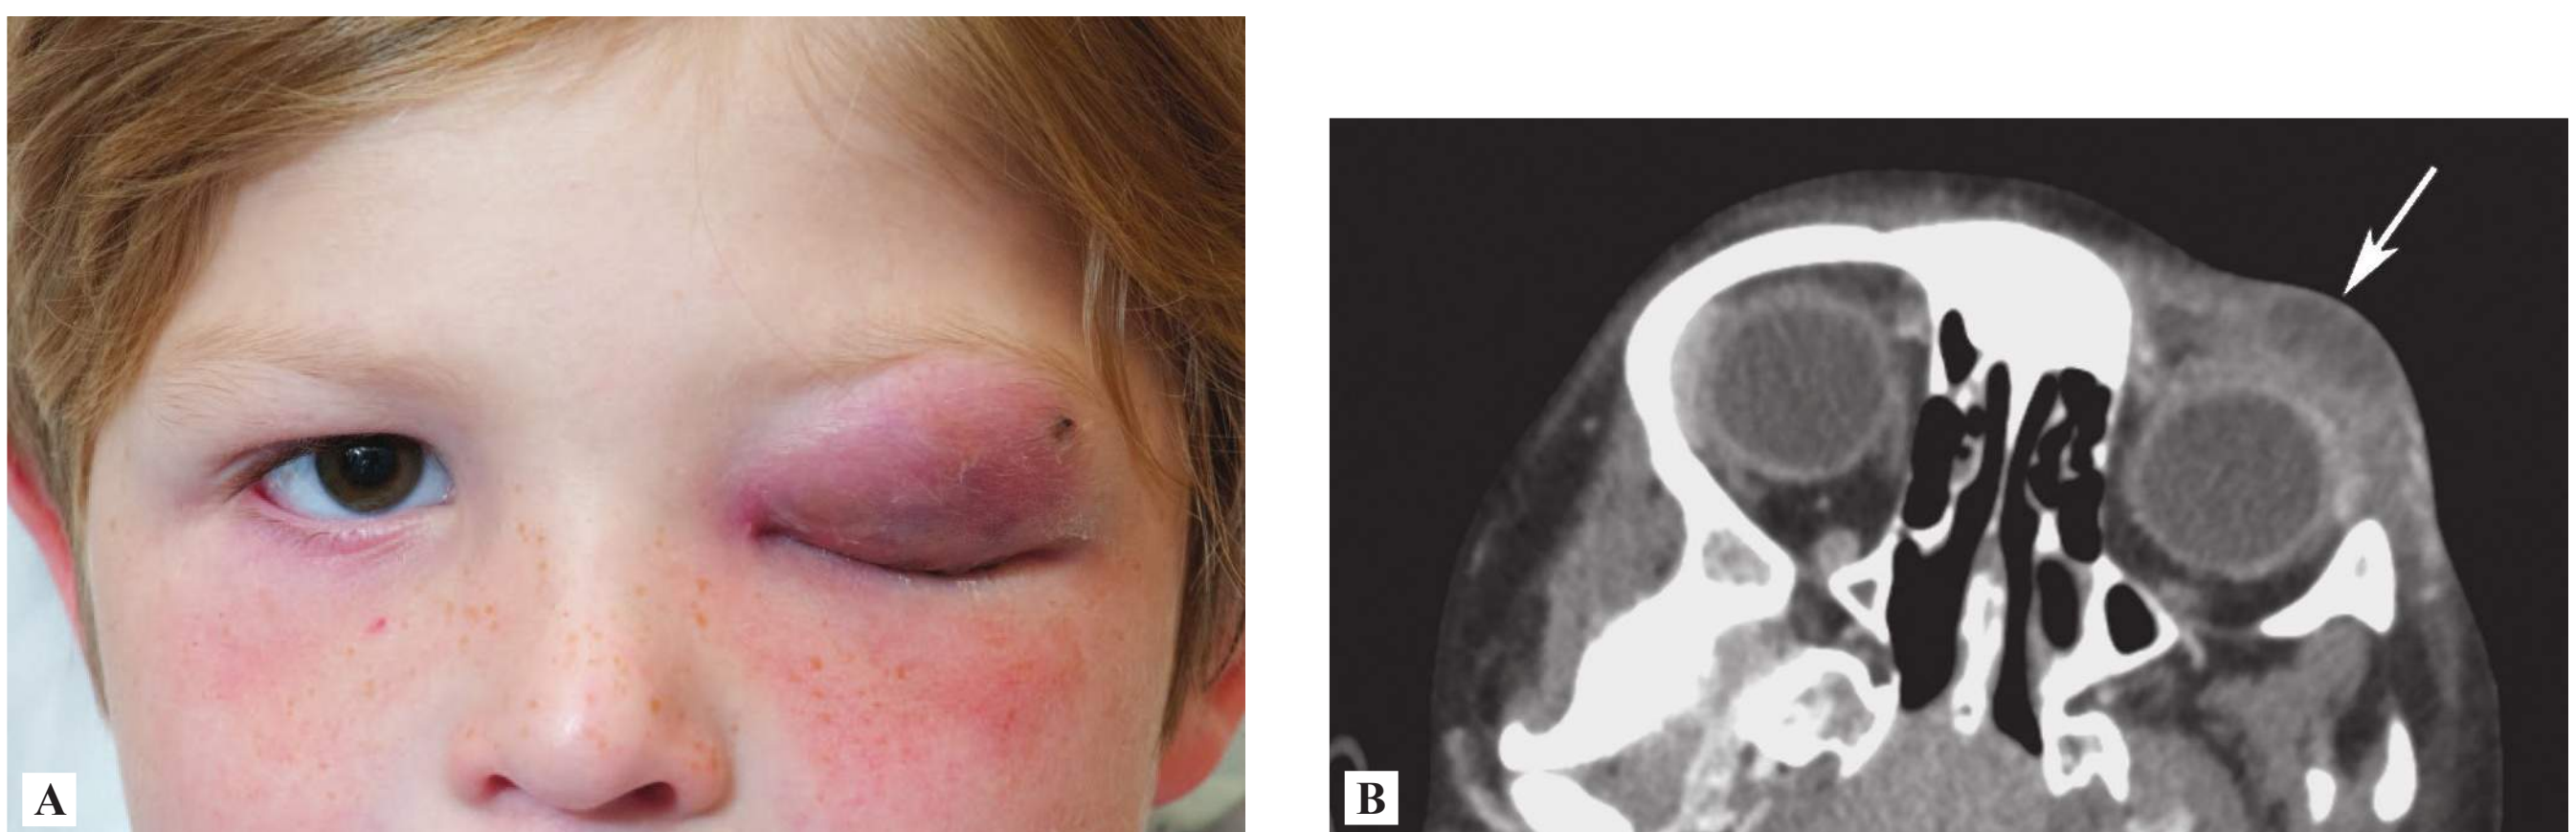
■ Preseptal Cellulitis. Periorbital cellulitis with abscess formation seen in this patient (A) and on CT (B). (Photo contributor: Eftitan Akam.)
